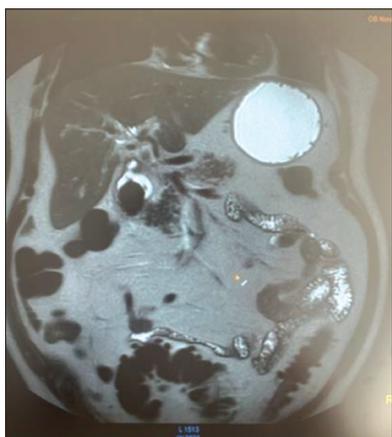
Magnetic resonance imaging – gallstone in the duodenum
